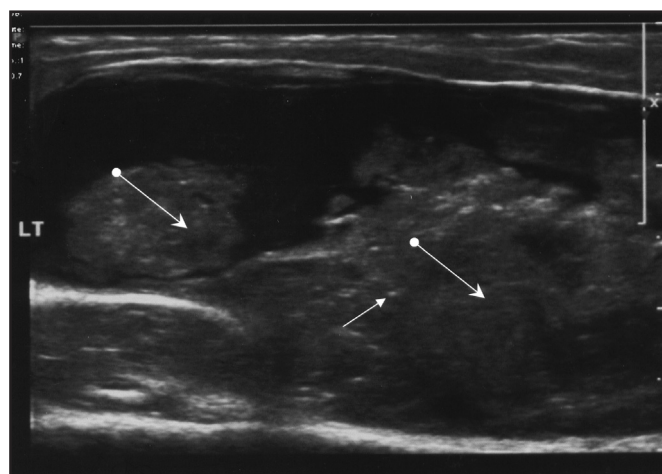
Ultrasound showed the mass to be composed of solid areas which reflect marked intraarticular pannus formation (arrow with rounded end) and cystic (dotted arrow) components representing fluid which can be variable in nature. The linear hyperechoic densities noted within the pannus are rice bodies (arrow head).
